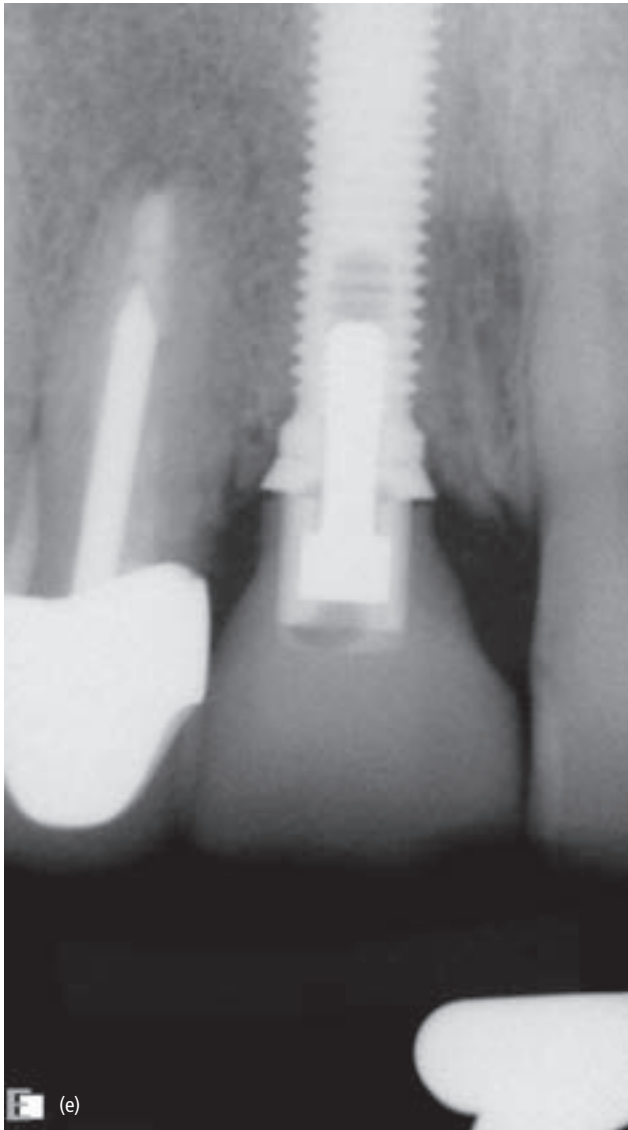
(cont'd) (e) A radiograph taken 8 years after restoration demonstrates the stability of the bone. (f) The patient presented 8 years after restoration with slightly inflamed tissue, but clinically gingival heights are similar to those present immediately after restoration.
